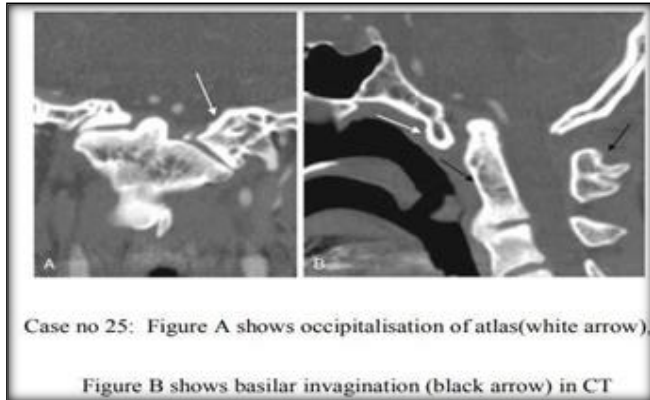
Case No. 25 — CT axial images showing occipitalisation of atlas (white arrow, Figure A) and associated basilar invagination (black arrow, Figure B).
